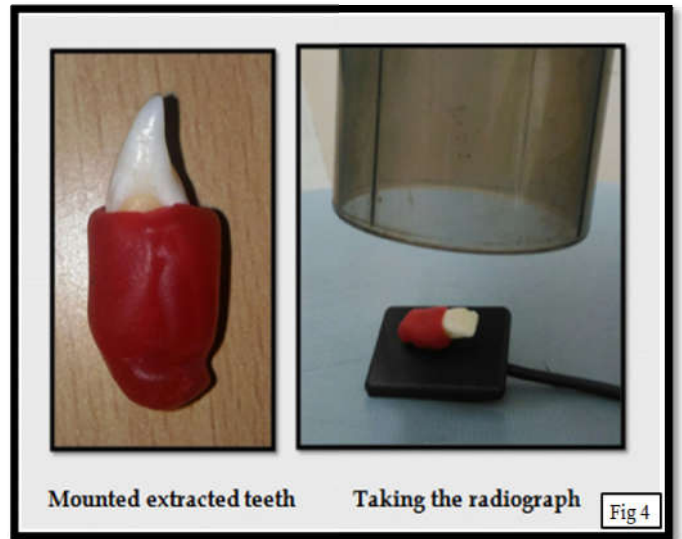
Mounting the extracted teeth and taking the radiograph
